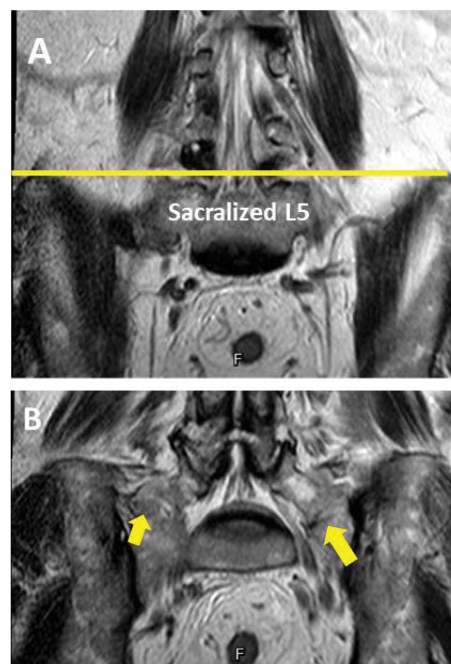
A) Coronal T2 MRI image shows less than 1¼ vertebral bodies below the tangent line (yellow line), indicating a negative iliac crest tangent sign and sacralized L5. B) Coronal T2 MRI shows a sacralized L5 with Castellvi type 3B LSTV. Yellow arrows indicate bilateral complete sacralization due to the total bony union of transverse processes to the sacrum.
